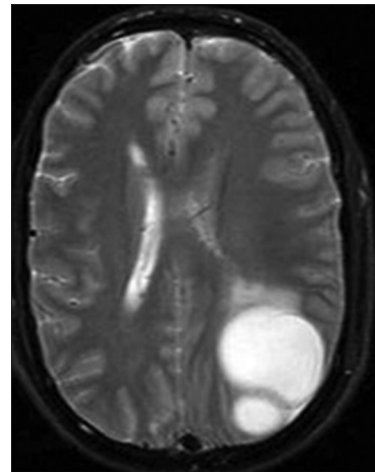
Brain hydatid cyst in left parietotemporal lobes (magnetic resonance imaging, axial cut)
